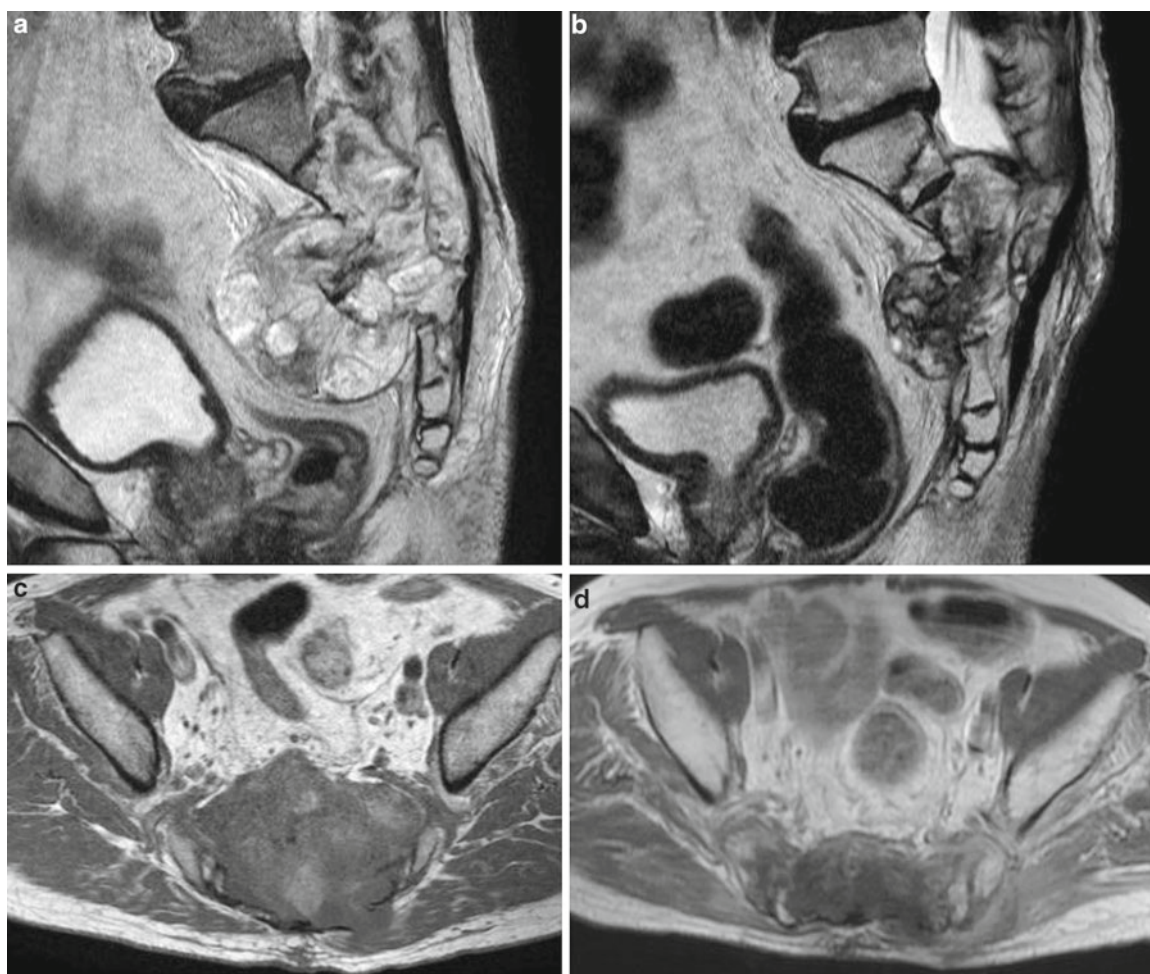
(a) T2-weighted sagittal MRI before carbon ion radiotherapy. (b) T2-weighted sagittal MRI 4 years after carbon ion radiotherapy. (c) T1-weighted axial MRI with a contrast medium before carbon
